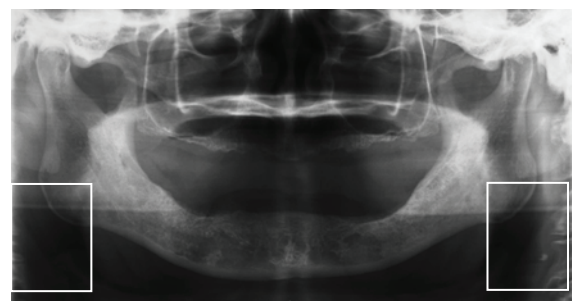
Example of a dental panoramic radiograph.
